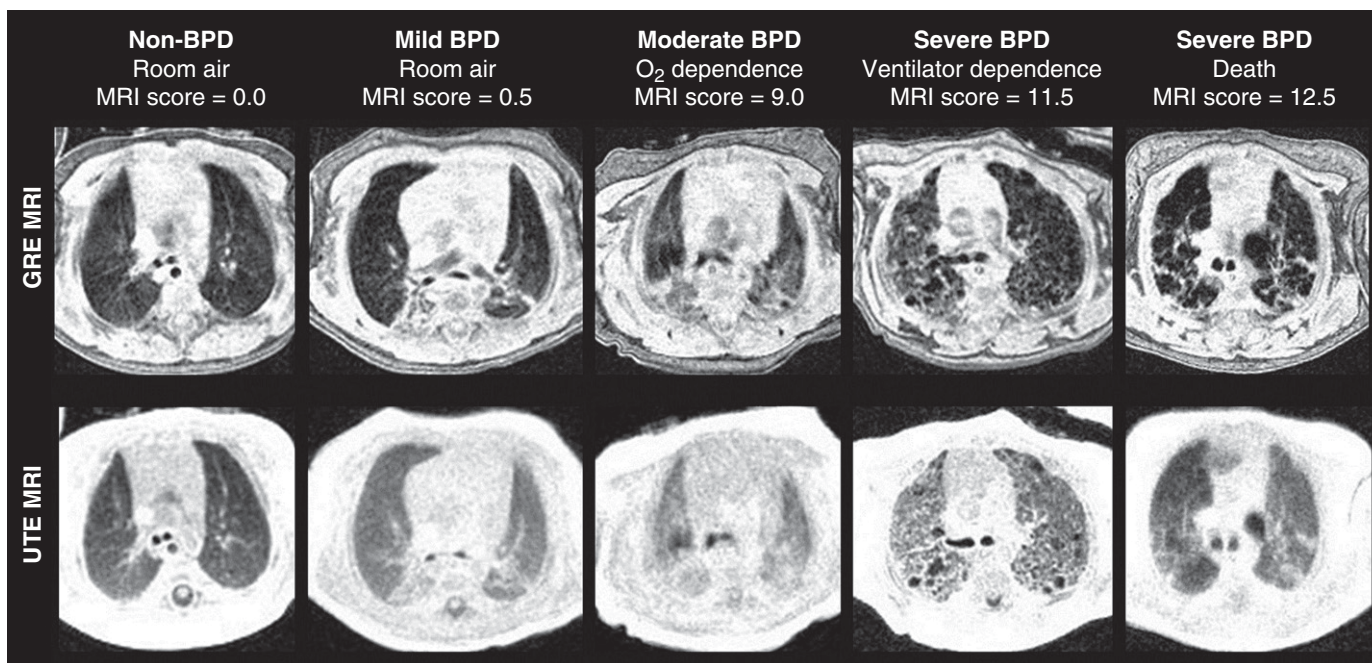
Representative axial gradient echo (GRE) and ultrashort echo time (UTE) magnetic resonance imaging (MRI) demonstrating the range of bronchopulmonary dysplasia (BPD) severity. The level of respiratory support at neonatal ICU discharge and MRI scores are provided for each subject. Owing to its relatively short TE value, the UTE sequence can visualize hypodense tissue with intensity above the noise floor, whereas, in the same tissue, the GRE image is reconstructed with intensity near that of noise, even when non-zero density is present and apparent on UTE (for example, in the deceased severe BPD case at far right). In this way, UTE contrast weighting yields density-like intensities between various pulmonary tissues. On the other hand, with its relatively long TE value, the GRE sequence can yield improved contrast between fibrotic/interstitial/soft tissues and normal/hypodense parenchymal tissues, even though it does not represent accurate density measures of tissue with rapid effective transverse relaxation time decay.
